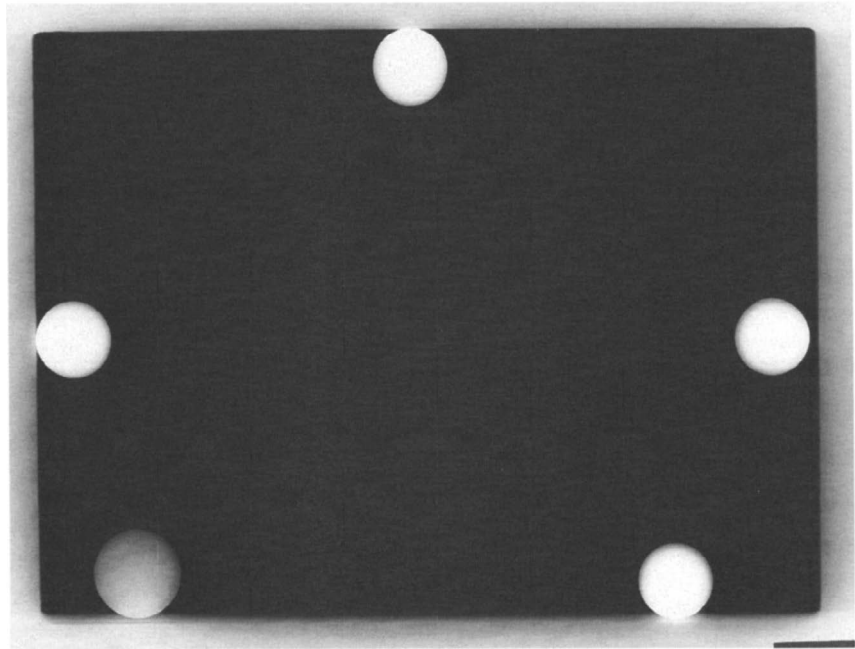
Sample collimation assessment film. A film exposed in the top cassette; the exposed area indicates the extent of the X-ray field. The outer edges of the four smaller coins indicate the edges of the light field. The outer edge of the larger coin (lower left) indicates the inner chest-wall edge of the compression paddle.
